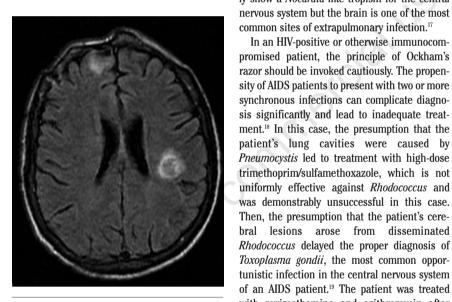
Magnetic resonance image of the brain two weeks after re-admission.
